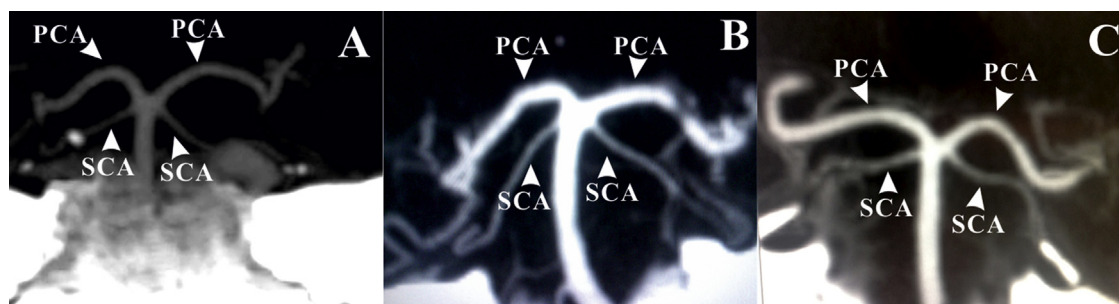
Computed Tomography Angiography – maximum intensity projection images. Type 4a (A); Type 4b (B); Type 5b (C). PCA – posterior cerebral artery; SCA – superior cerebellar artery.
